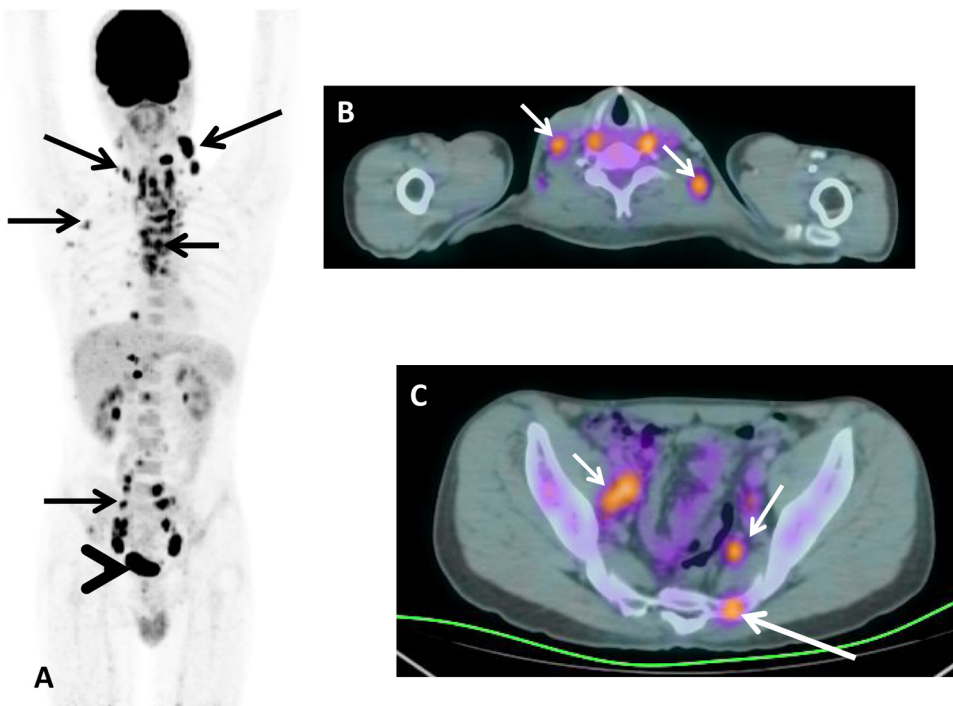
^{18}F -FDG PET/CT scan showing nodal extrapulmonary tuberculosis in a 28-year-old male patient. Biopsy of the left cervical node confirmed tuberculosis. (A) Whole-body projection is shown. The black arrows indicate, from top to bottom, F-FDG uptake in bilateral cervical nodes, right axillary node, mediastinal nodes, and right pelvic nodes. The arrow head at the bottom shows excreted activity in the urinary bladder. (B) Transaxial fused images at the level of the cervical region showing the left and right cervical nodes (small white arrows). (C) Transaxial fused images at the level of the pelvis region showing left and right pelvic side wall nodes (small white arrows) and a lesion in the left sacral region (long white arrow).
